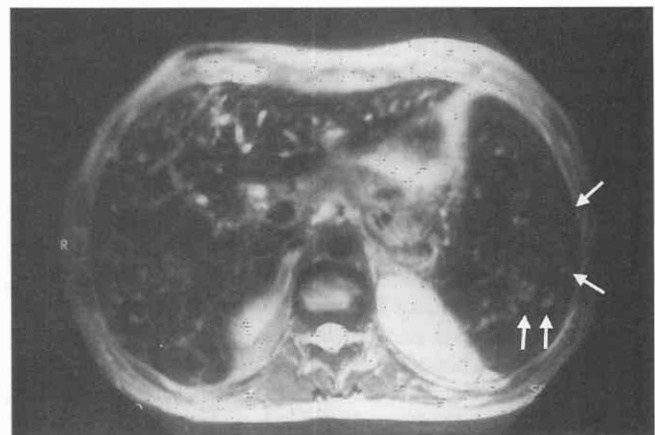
T2-weighted MR image demonstrates multiple small foci of increased signal (arrows) in both the spleen and the liver consistent with acute fungal abscesses. The spleen and liver are diffusely decreased in signal because of iron overload from multiple transfusions.
